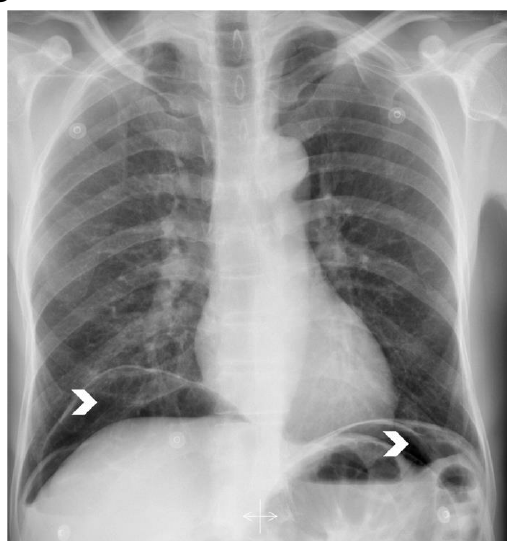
Chest radiography. *Perforated duodenal ulcer: lucent areas of free intraperitoneal gas (white arrowheads).*
